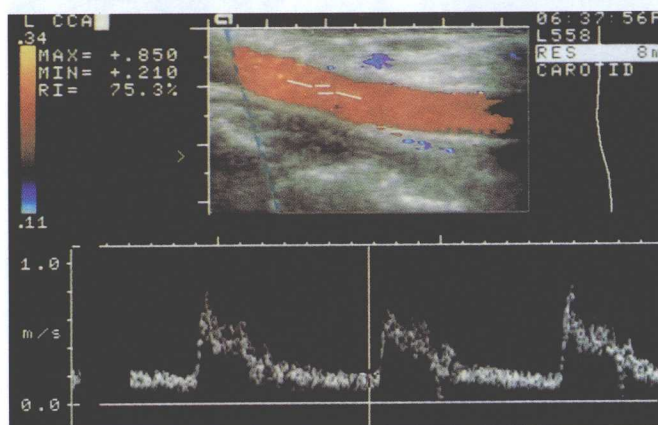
Normal carotid artery. Colour Doppler showing the gate where the flow-velocity waveform has been taken. Bottom: flow-velocity waveform. The peaks represent systolic blood flow.
